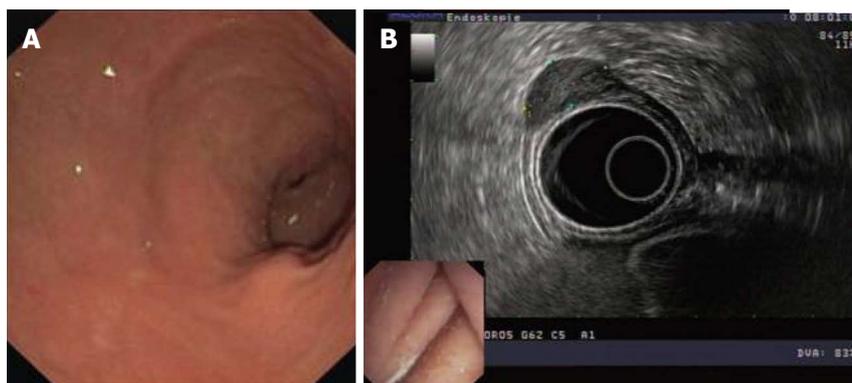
Typical endoscopic features of an early gastrointestinal stromal tumors of the stomach. A: Endoscopic image of an early GIST of the stomach; B: Endosonographic image of an early GIST of the stomach. Modified from reference [33]. GIST: Gastrointestinal stromal tumors.
